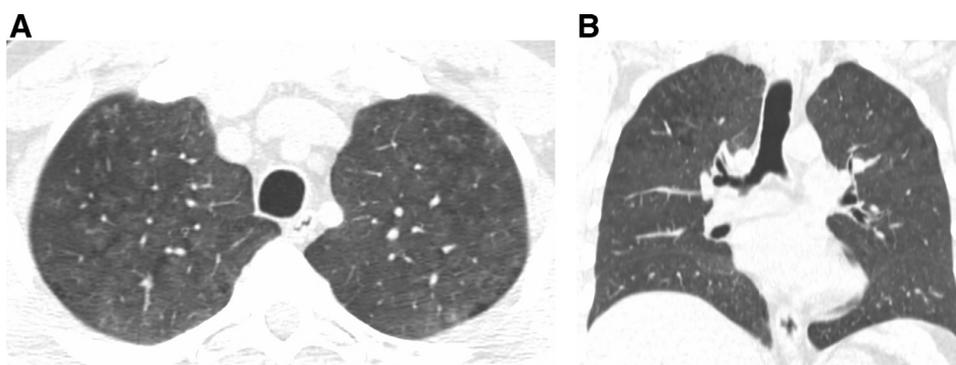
A 35-year-old male smoker with respiratory bronchiolitis-associated interstitial lung disease. Axial (A) and coronal reformatted (B) CT images show extensive mid and upper lung predominant ground-glass opacity. Minimal upper lobe emphysema is present.
